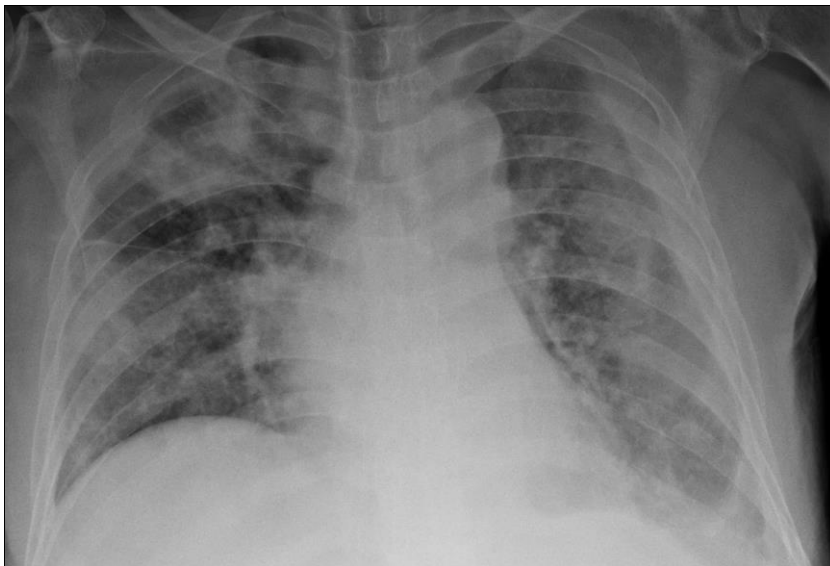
Chest radiograph showing increase in multifocal patchy opacities
